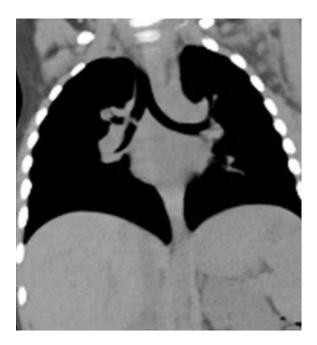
Coronal CT section obtained with mediastinal window; foreign body in soft tissue density of right main bronchus. After bronchoscopy, the object was identified to be a piece of peanut.
